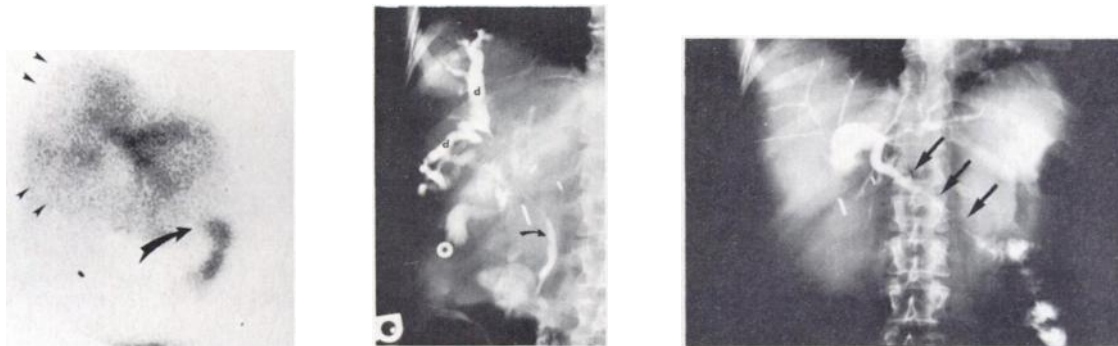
Case 2. Left: Tc-99m HIDA scintigram, 1 hr after tracer injection, oblique view. Bile ducts are seen within right lobe as multiple photon-deficient defects (arrowheads). Patency of left cholangiojejunostomy is demonstrated (curved arrow). Center: Percutaneous transhepatic cholangiogram. Puncture of right bile ducts reveals marked dilatation of multiple ducts (d), with distortion of portal anatomy and patency of distal common bile duct (curved arrow). Right: Percutaneous transhepatic cholangiogram. Puncture of left bile ducts reveals mild dilatation, but surgical anastomosis is patent (arrows).
